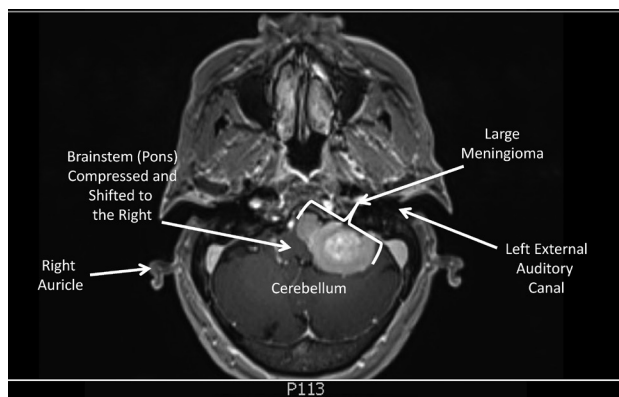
This axial T1-weighted post-gadolinium enhanced image shows a large meningioma of the left cerebellopontine angle that is compressing the brainstem, shifting it to the right.
